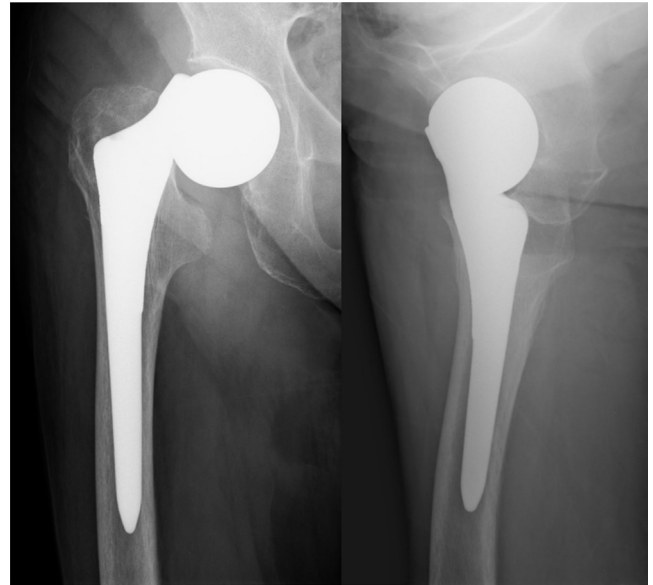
Anteroposterior radiograph film obtained immediately after implantation of the right bipolar hemiarthroplasty. There are no obvious abnormalities.
